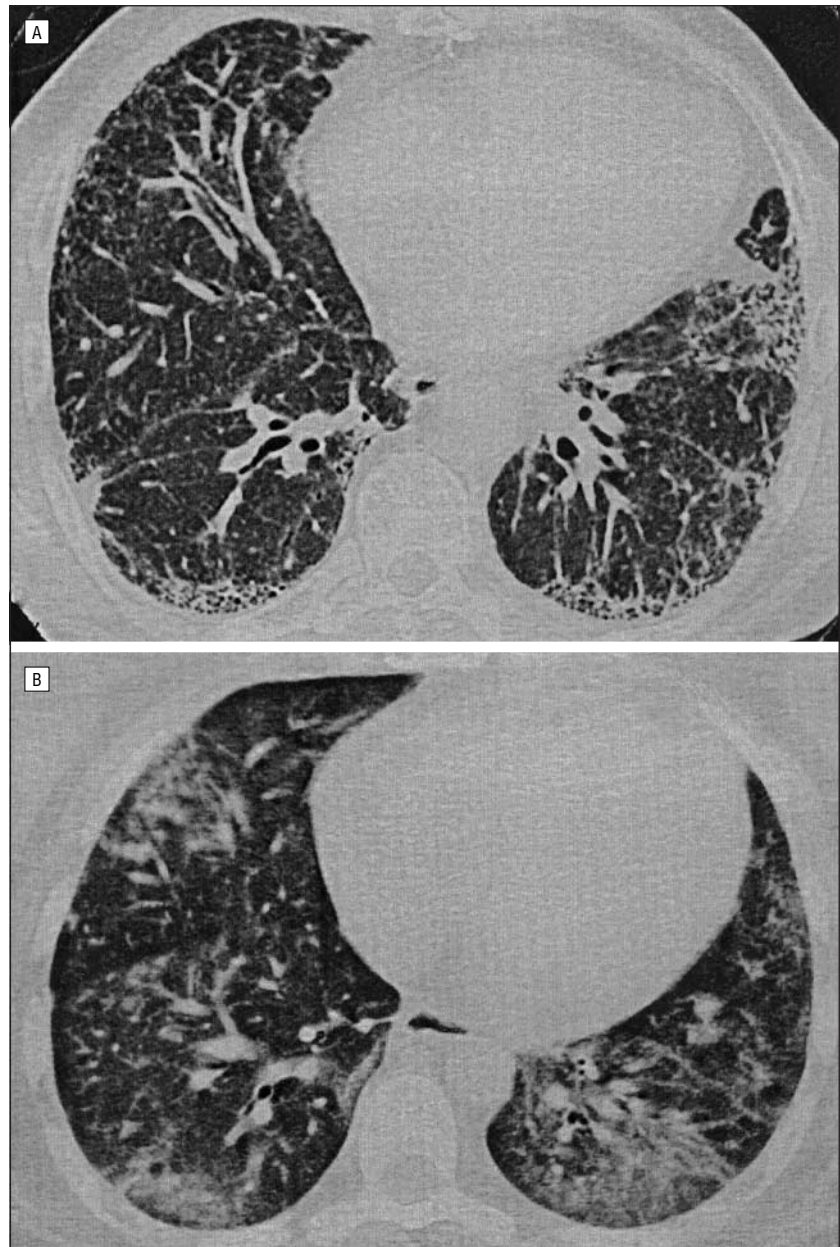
High-resolution computed tomography (HRCT) findings in idiopathic interstitial pneumonia. A, HRCT of the chest in a patient with idiopathic pulmonary fibrosis. A representative HRCT chest image shows bilateral, patchy, subpleural reticular opacities with evidence of subpleural honeycombing. B, HRCT of the chest in a patient with nonspecific interstitial pneumonia. A representative HRCT chest image shows bilateral, patchy, subpleural ground-glass opacities without evidence of subpleural honeycombing.
